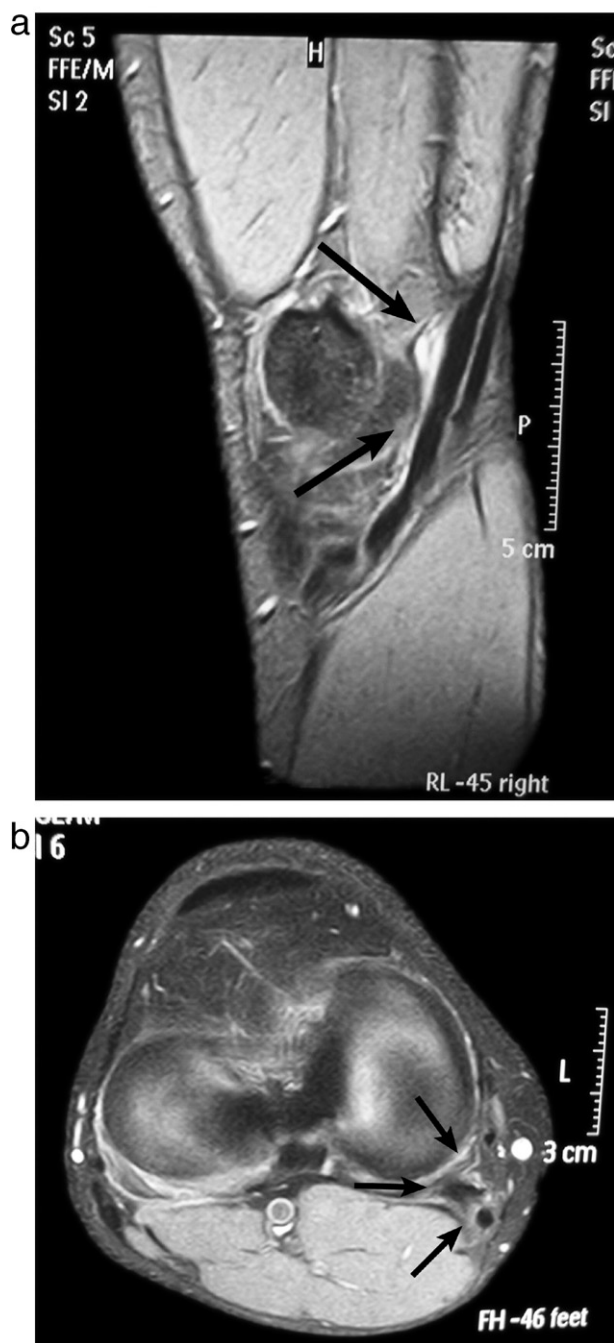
a. MRI (sagittal view) showing existence of fluid in the semimembranosus bursa and the sheath surrounding the semitendinosus and gracilis (arrows) (Philips Intera 1.5 T, Philips Medical Systems Holland BV, Sequence: T2 WFFE). b. MRI (transverse view) showing fluid in the semimembranosus bursa and surrounding oedematous fat (arrows) (Philips Intera 1.5 T, Philips Medical Systems Holland BV, Sequence: T2 WFFE).
